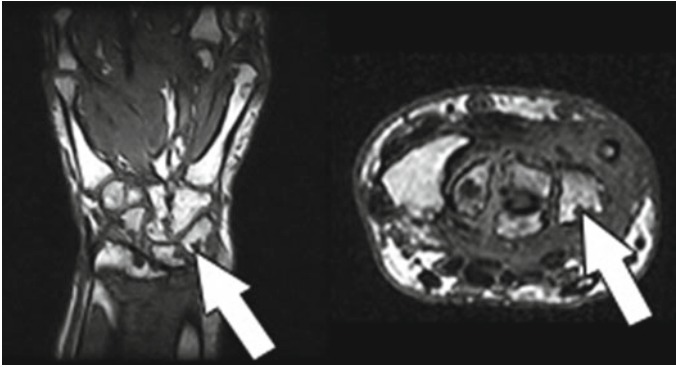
MRI of a wrist affected by RA and with bone erosions. The *white arrows* indicate on the coronal plane (*left*) and on the axial plane (*right*), the erosion of the triquetral bone
